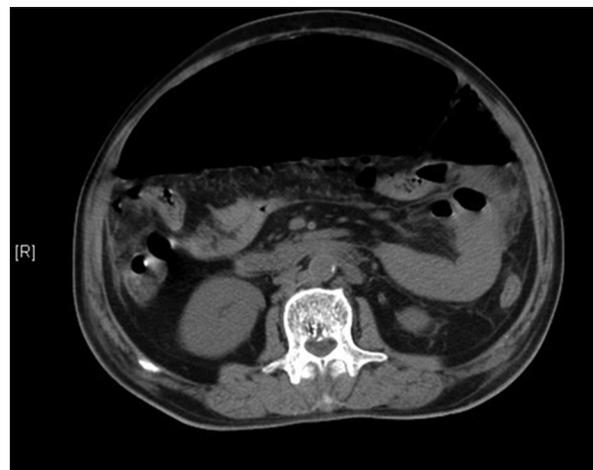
Computed tomography abdomen of the patient showing pneumoperitoneum
